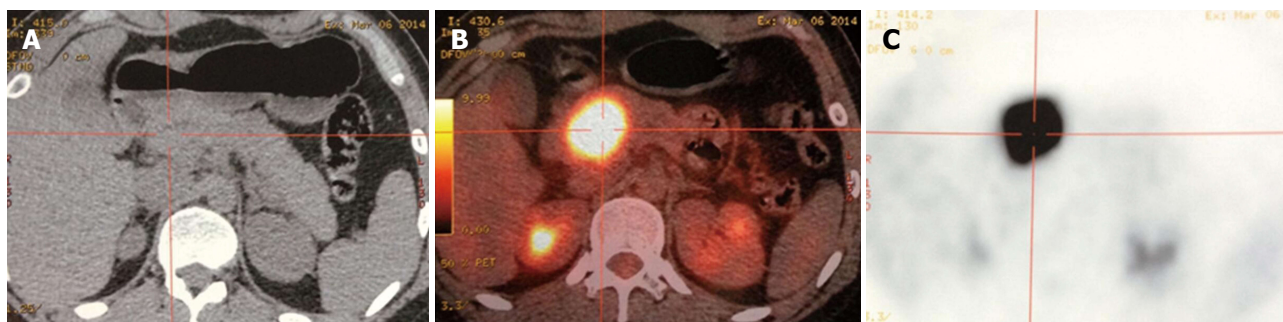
High uptake of F-18-fluorodeoxyglucose in a patient with solid pseudopapillary tumor of the pancreas. SPTP in a 25-year-old female patient with a T2 stage tumor. A: CT scan revealed a 5-cm isodense mass in the pancreatic head. B and C: Transaxial PET/CT (B) and PET (C) showed a hypermetabolic lesion with the maximum standardized uptake value of 33. She was disease free for 32 mo after surgical resection. SPTP: Solid pseudopapillary tumor of the pancreas; PET/CT: Position emission tomography/computed tomography.
